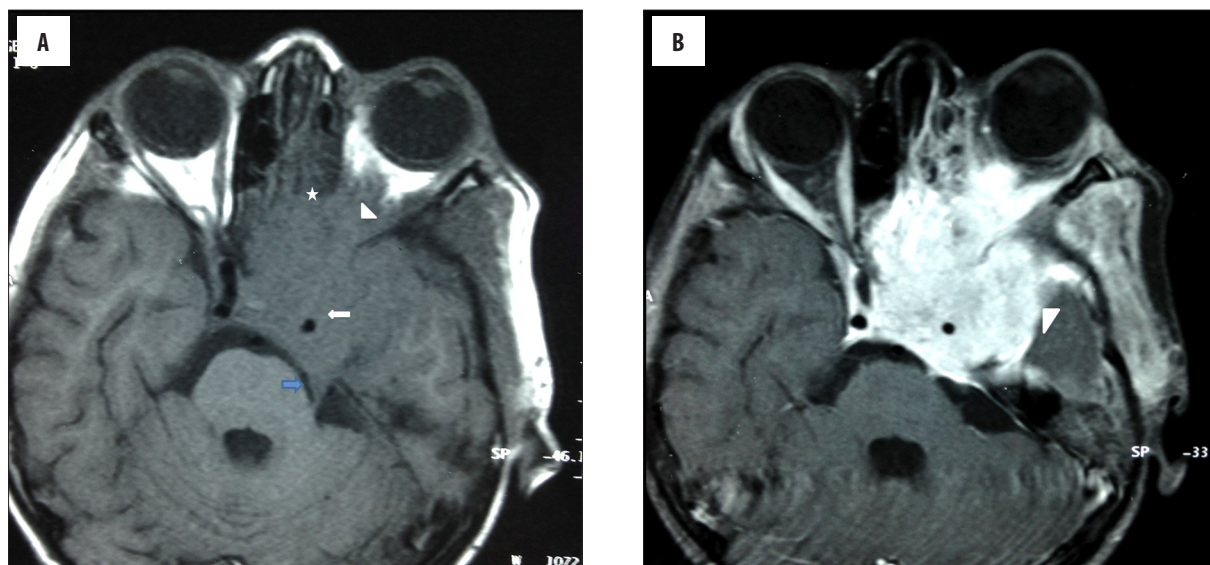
A 7-year-old boy with a huge nasopharyngeal mass (case 10) extending to the sphenoid/ethmoid sinus (star) on the anterior side, to the left orbit (arrow head) and prepontine cystern (blue arrow) on the posterior side, cavernous sinus, and the middle fossa (arrow head) on the lateral side. Carotid encasement is also seen (white arrow). The mass is slight hyperintense compared to the muscle on T1-weighted images (A) and showing intense homogenous enhancement after contrast administration (B).
